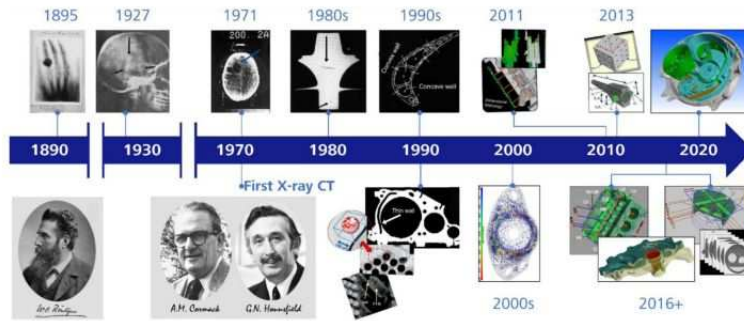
Improvement and development of X-ray technologies through years, from the first radiography to non-destructive measurements for industrial application, passing through the invention of the first tomographer. Image taken from [79].
